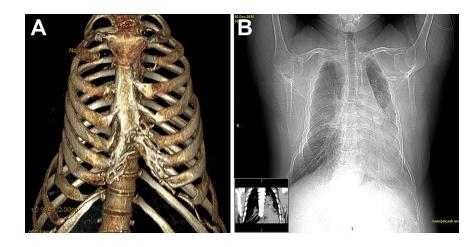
(A) Three-dimensional computed tomographic image of a 42-year-old male patient with acquired thoracic dystrophy (ATD). (B) Chest roentgenogram and computed tomographic scan of same patient with ATD demonstrating restricted thoracic space and left-sided cardiac displacement.
